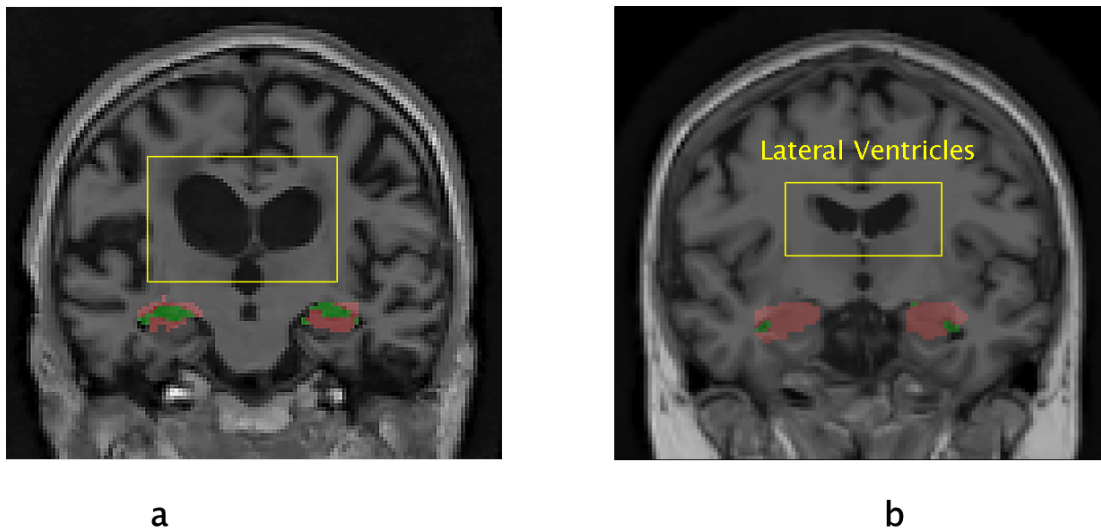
CSF on the hippocampus region : a) AD brain, b) Healthy: MRI slices in coronal projection
